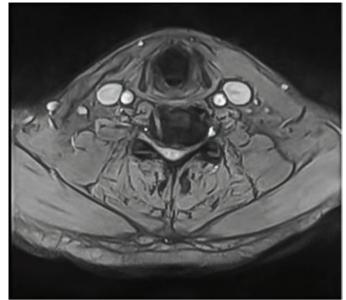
(a, b) MRI scans
